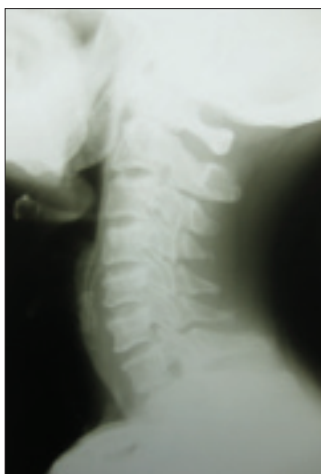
Preoperative lateral view neck radiograph showing thumb sign
